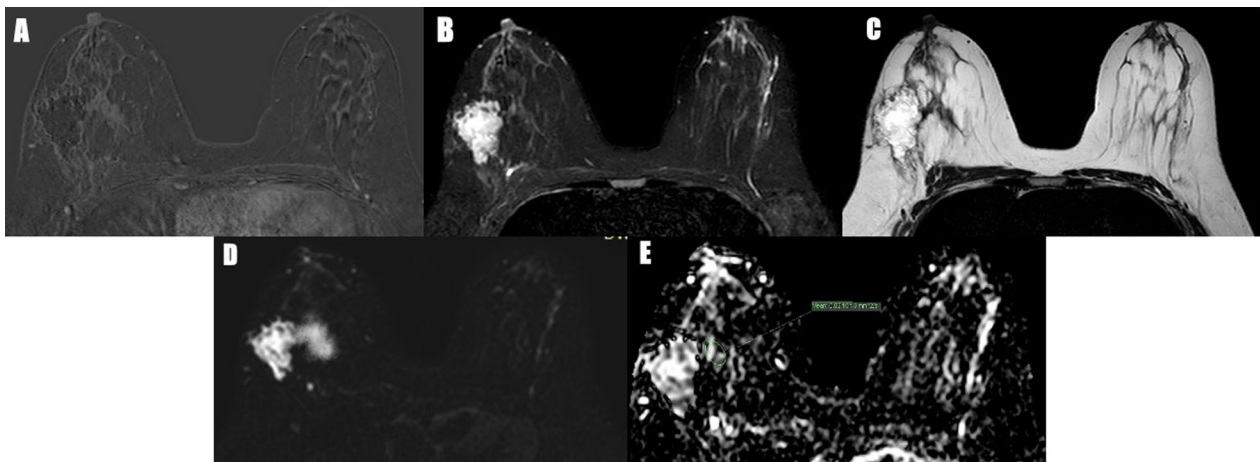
34 years old female with a history of right breast grade II infiltrating ductal carcinoma underwent breast conservative surgery 4 months ago and complained of persistent operative bed pain and heaviness, ultrasound was done revealing a post-operative hematoma with a medially located small area of parenchymal heterogeneity, post-contrast MRI was done and revealed: A Subtracted image: shows enhanced right nipple associated with right breast post-operative hematoma which shows thick ring enhancement associated with heterogeneous non-mass enhancement just medially to the hematoma. B STIR image: shows bright SI of the hematoma with a medially related area of intermediate SI. C T2WI: The right breast post-operative hematoma shows mixed high and intermediate SI with medially related area of low SI. D DWI: The hematoma as well as the related non-mass shows restricted diffusion. E ADC map: The hematoma as well as the medially related non-mass enhancement shows low ADC value = $0.82 \times 10^{-3} \text{ mm}^2/\text{s}$. Pathologically proved to be right breast grade II invasive ductal carcinoma, ER negative, PR negative, KI 67 42%, HER 2 positive 3. (STIR: short T1 inversion recovery, SI: signal intensity, WI: weighted imaging, DWI: diffusion weight imaging, ADC: apparent diffusion coefficient, ER: estrogen receptor, PR: progesterone receptor, HER2: human epidermal growth factor receptor 2)
